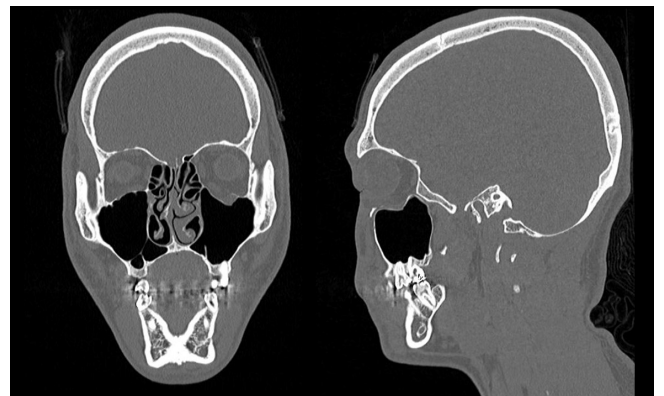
Follow-up CT (PTD 17) showing interval worsening with increased orbital floor depression.
